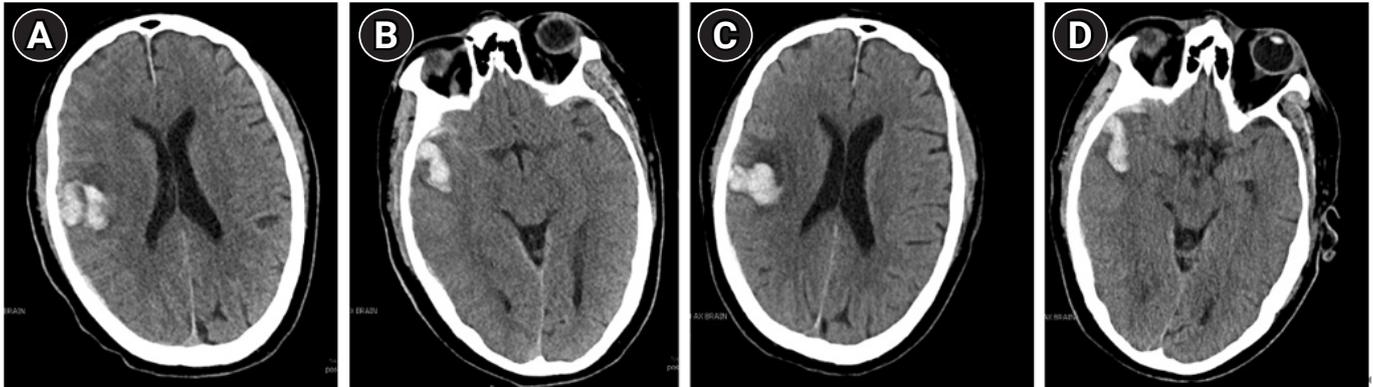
Computer tomography (CT) without contrast. (A, B) CT head on arrival revealing new intraparenchymal hematomas in the frontoparietal and anterior temporal lobes, sulcal effacement, and mass effect of the right lateral ventricle. (C, D) Repeat CT showing stability of the subarachnoid hemorrhage, frontoparietal hematoma, and anterior temporal hematoma.
